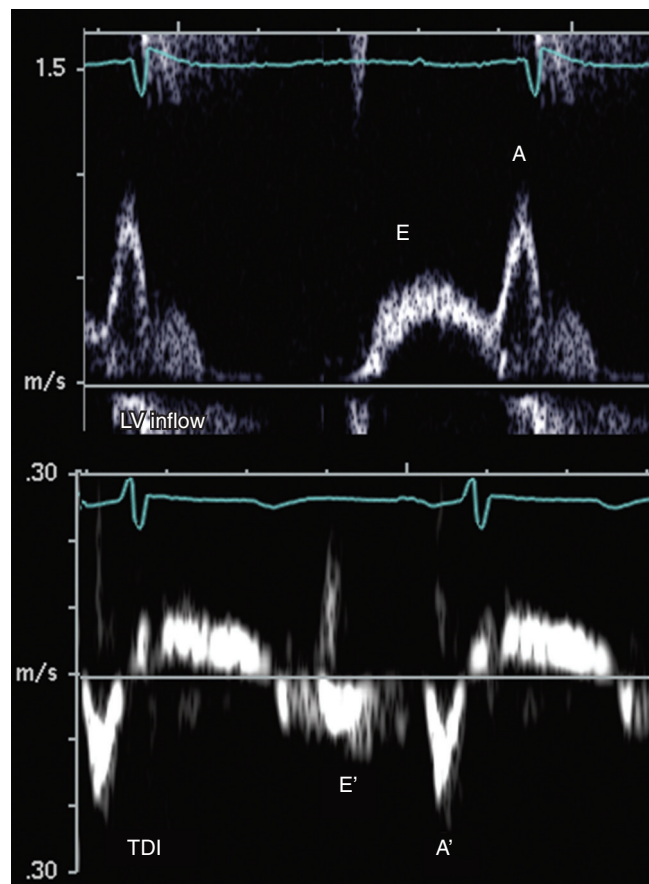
■ Doppler indices for mild diastolic function. With impaired ventricular relaxation, peak early mitral inflow velocity is decreased. Increased reliance on atrial contribution to ventricular filling leads to reversal of the E:A ratio on the left ventricular (LV) inflow tracing. A ratio of LV inflow E wave to tissue Doppler velocity (TDI) E' wave (E:E' ratio) less than 8 implies normal left atrial pressure. In this case, E:E' = 0.6/0.1 = 6.
